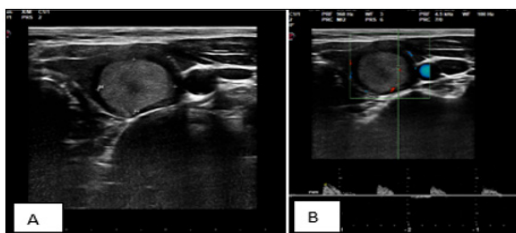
ATA Thyroid Nodule Sonographic Pattern - High Suspicious for Malignancy. Pathological diagnosis was Malignancy – Bethesda V.
